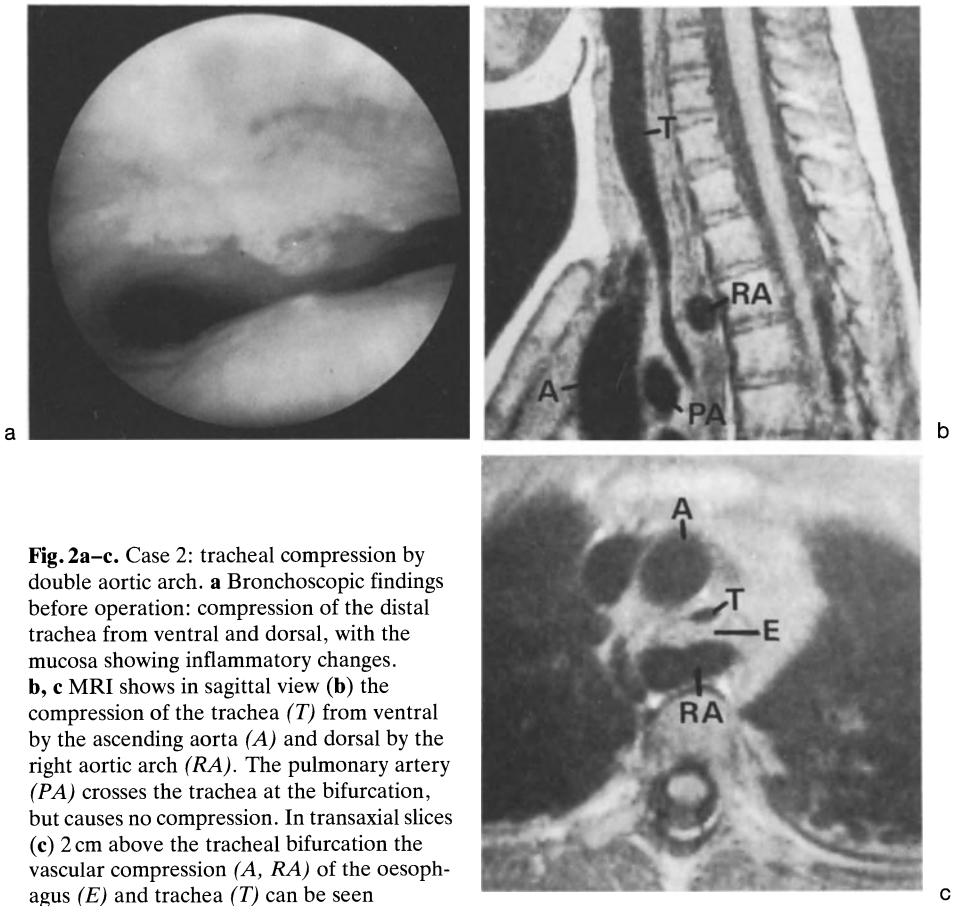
Case 2: tracheal compression by double aortic arch. a Bronchoscopic findings before operation: compression of the distal trachea from ventral and dorsal, with the mucosa showing inflammatory changes. b, c MRI shows in sagittal view (b) the compression of the trachea (*T*) from ventral by the ascending aorta (*A*) and dorsal by the right aortic arch (*RA*). The pulmonary artery (*PA*) crosses the trachea at the bifurcation, but causes no compression. In transaxial slices (c) 2 cm above the tracheal bifurcation the vascular compression (*A, RA*) of the oesophagus (*E*) and trachea (*T*) can be seen
